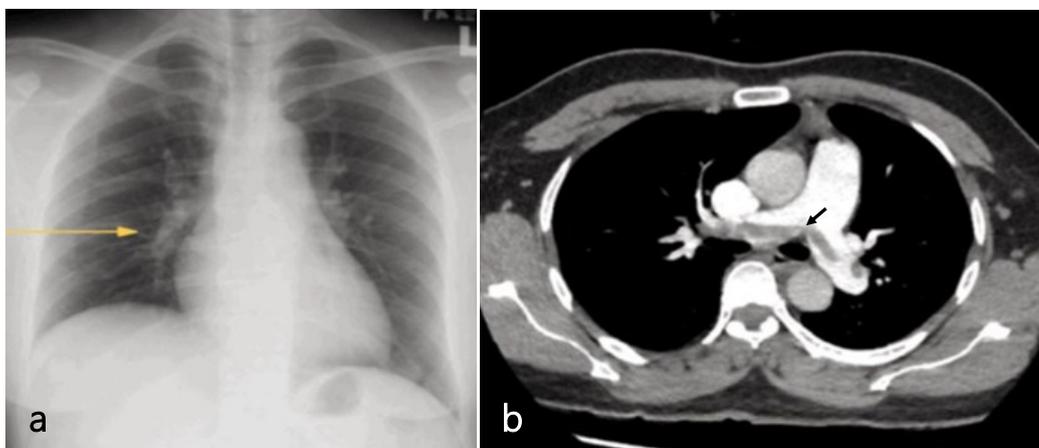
a) Chest radiograph showing Palla's sign (yellow arrow), b) CTPA demonstrating a long saddle pulmonary embolism (arrow).
